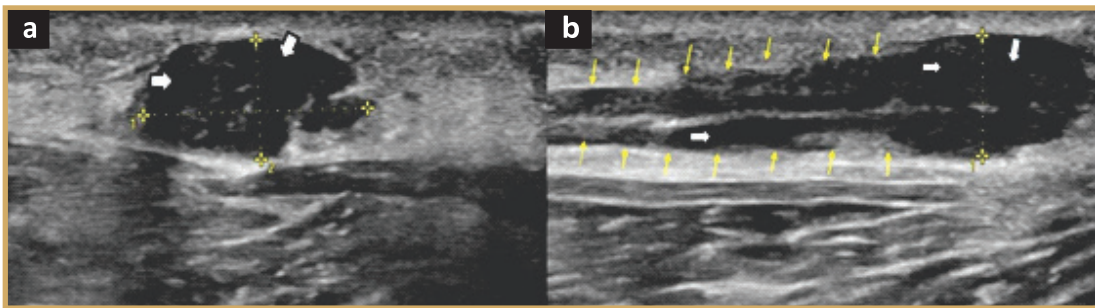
High resolution ultrasound (axial view) of the right common peroneal nerve (denoted by the yellow dotted lines & plus sign) depicting diffusely thickened right common peroneal nerve with hypoechoic areas within (denoted by the white arrows) suggestive of nerve abscess.
